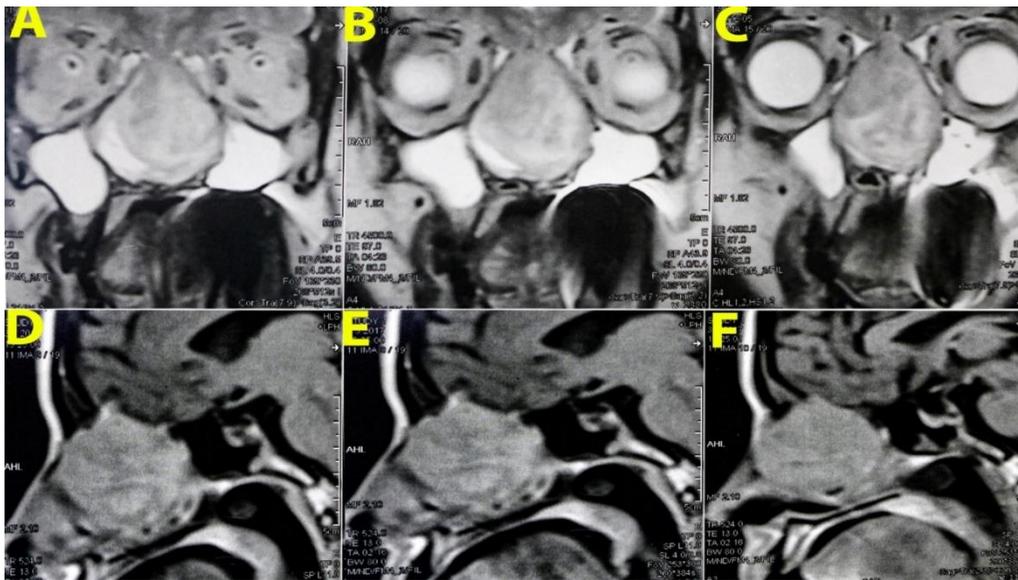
MRI nose and PNS with brain cuts. A, B & C) T2 weighted images coronal cuts showing heterogenous huge nasal mass destroying nasal septum and occupy the whole nasal cavity with intracranial extension. D, E&F) T1 weighted images sagittal cuts depicting the intracranial extension of the mass
